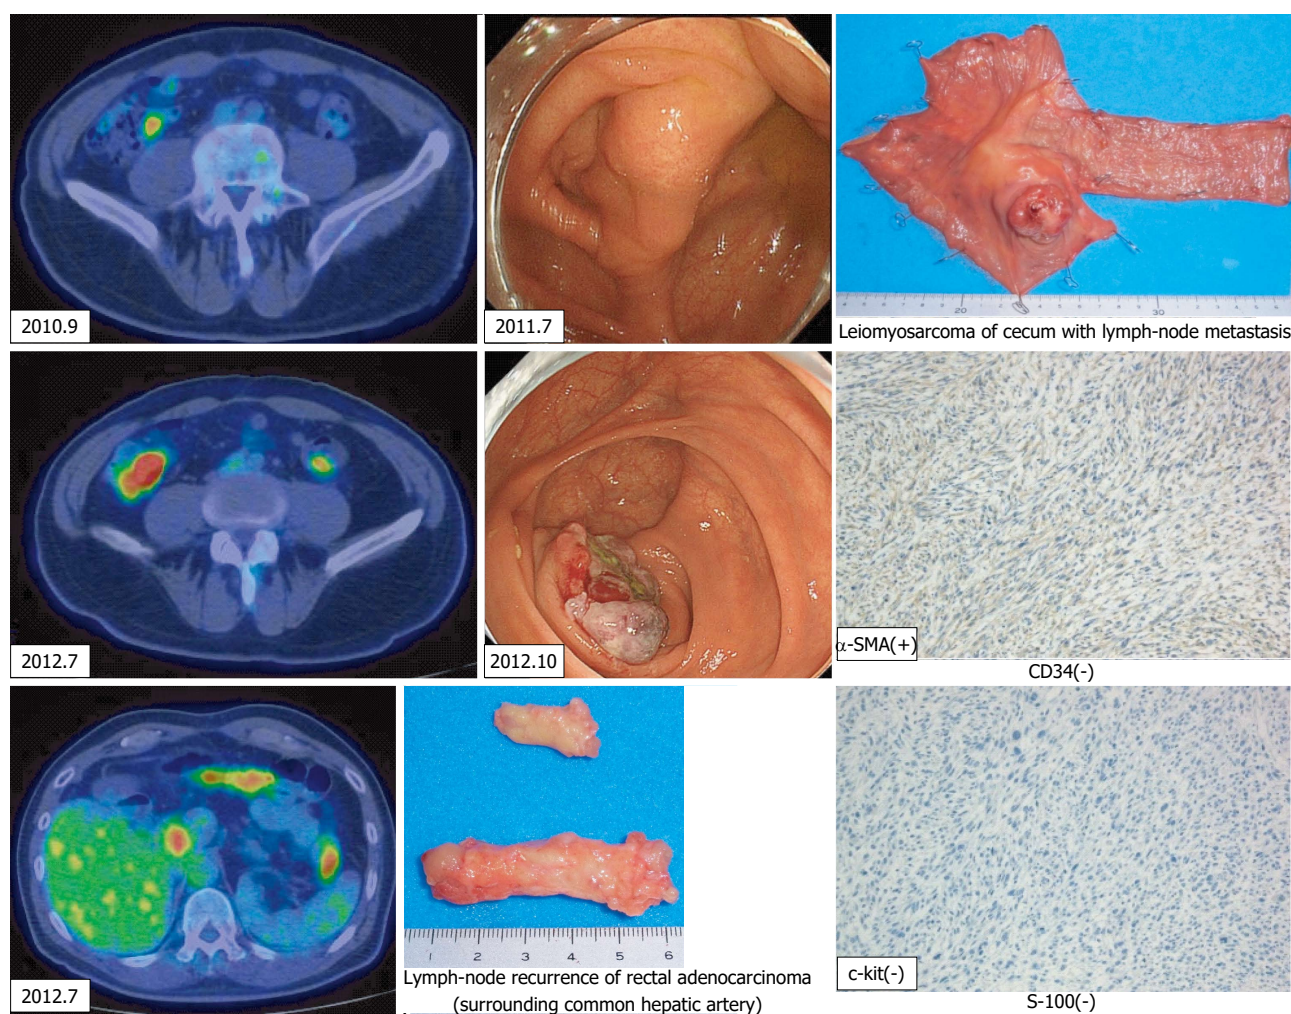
Cecal leiomyosarcoma and lymph-node recurrence. A cecal tumor and lymph-node swelling around the common hepatic artery were discovered in a positron emission tomography-computed tomography (PET-CT) scan. Retrospectively, accumulation had been observed in the cecum in a PET-CT scan in September 2010, and a submucosal tumor was suspected based on a colonoscopy taken in July 2011. SMA: Smooth muscle actin.
